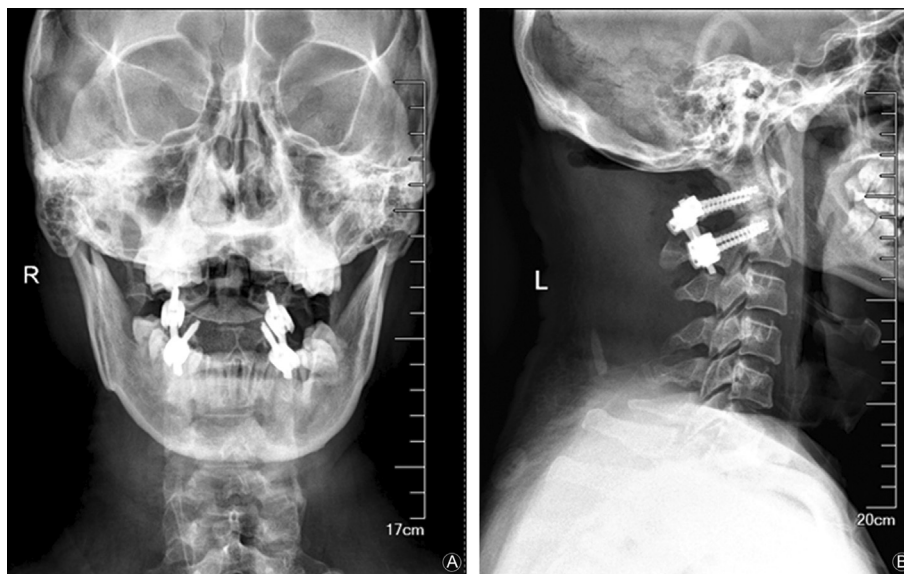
The postoperative anteroposterior (A) and lateral (B) radiographs showed a satisfactory position of instrumentation.
